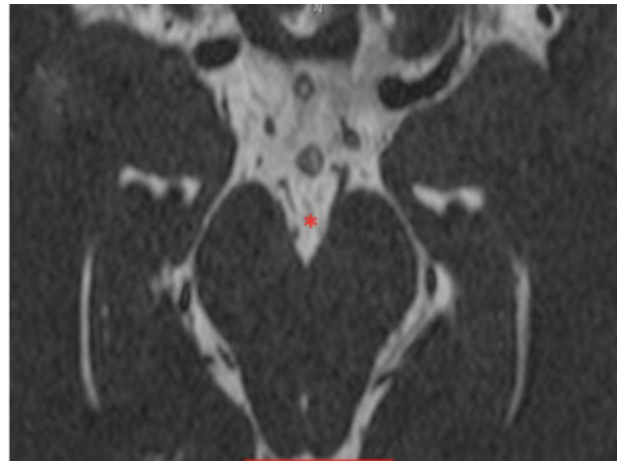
High-resolution CISS MR image of the mesencephalon showing the right oculomotor nerve is interruption– avulsion of right third nerve (asterisk).
